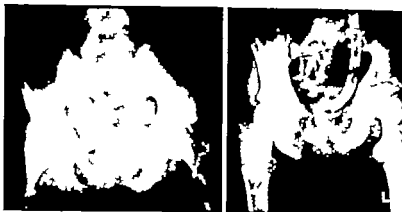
(left). Roentgenogram of pelvis 3 months after fractures of pelvis, ischia, and sacrum accompanied by rupture of urethra. Note only slight narrowing of pelvis and good horizontal alignment of acetabulum and iliac crests. The patient obtained also an excellent functional result and—as sliding—fib support of crutches 1 this time. Contrast with Figure 7.
